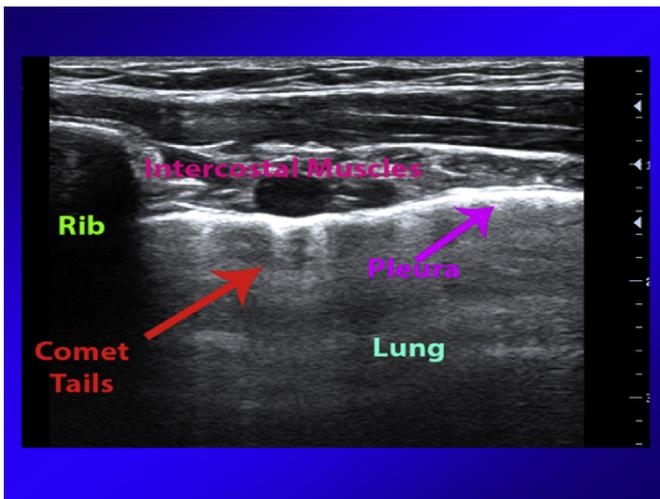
Ultrasound-guided intercostal nerve block anatomy.
